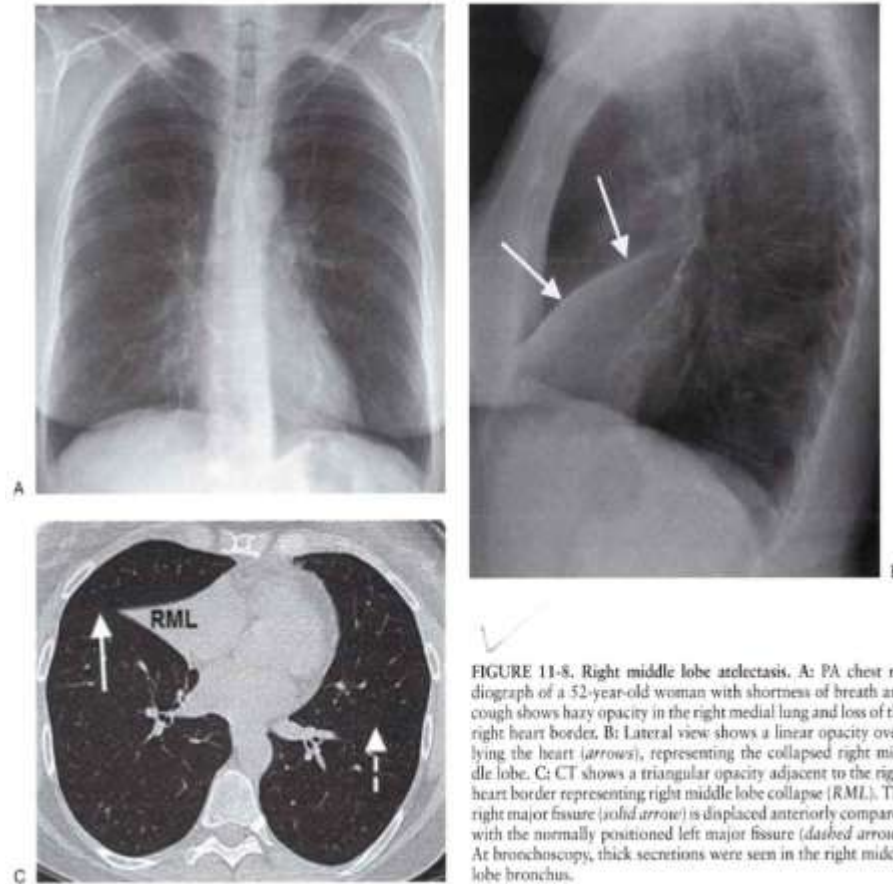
Right middle lobe atelectasis. A: PA chest radiograph of a 52-year-old woman with shortness of breath and cough shows hazy opacity in the right medial lung and loss of the right heart border. B: Lateral view shows a linear opacity overlying the heart (arrows), representing the collapsed right middle lobe. C: CT shows a triangular opacity adjacent to the right heart border representing right middle lobe collapse (RML). The right major fissure (solid arrow) is displaced anteriorly compared with the normally positioned left major fissure (dashed arrow). At bronchoscopy, thick secretions were seen in the right middle lobe bronchus.
